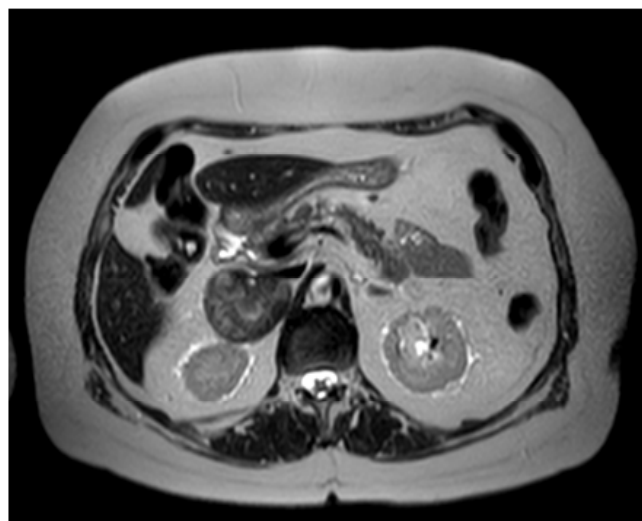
MRI showing BIBC metastases to right adrenal gland.
